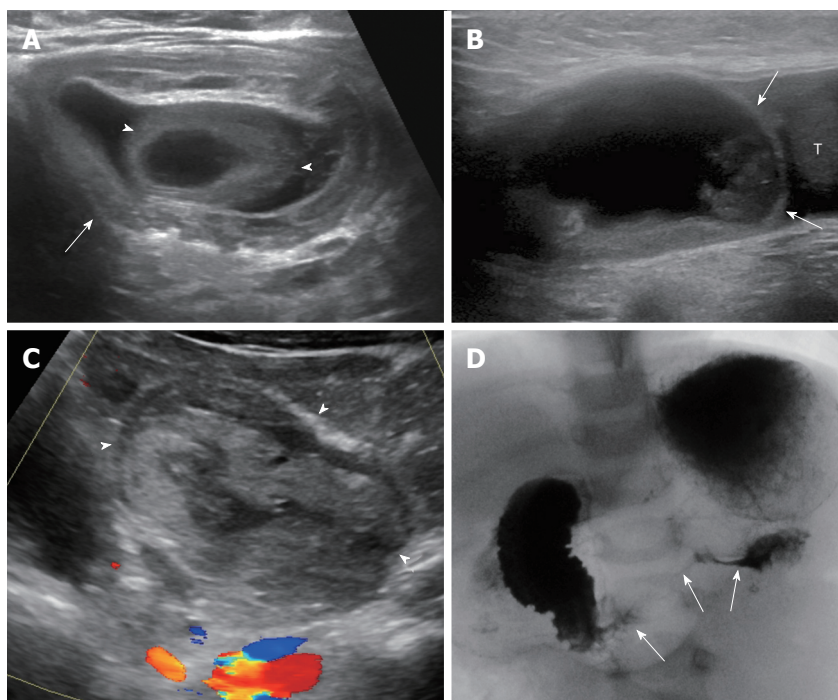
Acquired bowel disorders. A: Ileocolic intussusception with Meckel diverticulum as lead point. Six-month-old with small bowel obstruction on radiograph (not shown) and intussusception (arrow) demonstrated on ultrasound with lead point (arrowheads); B: Incarcerated inguinal hernia. Two-year-old boy with abdominal pain and left groin mass. Sagittal image of the left inguinal region show a cystic structure that did not clearly communicate with abdominal bowel loops (B, arrows; T = testicle). Testicular edema was also noted (not shown); C, D: Duodenal hematoma secondary to child abuse. One-year-old with abdominal pain and distension. Sagittal midline ultrasound image shows a complex mass in the expected location of the duodenum (C, arrowheads). Upper gastrointestinal series confirmed duodenal narrowing (D, arrows). Abuse was later confirmed.
